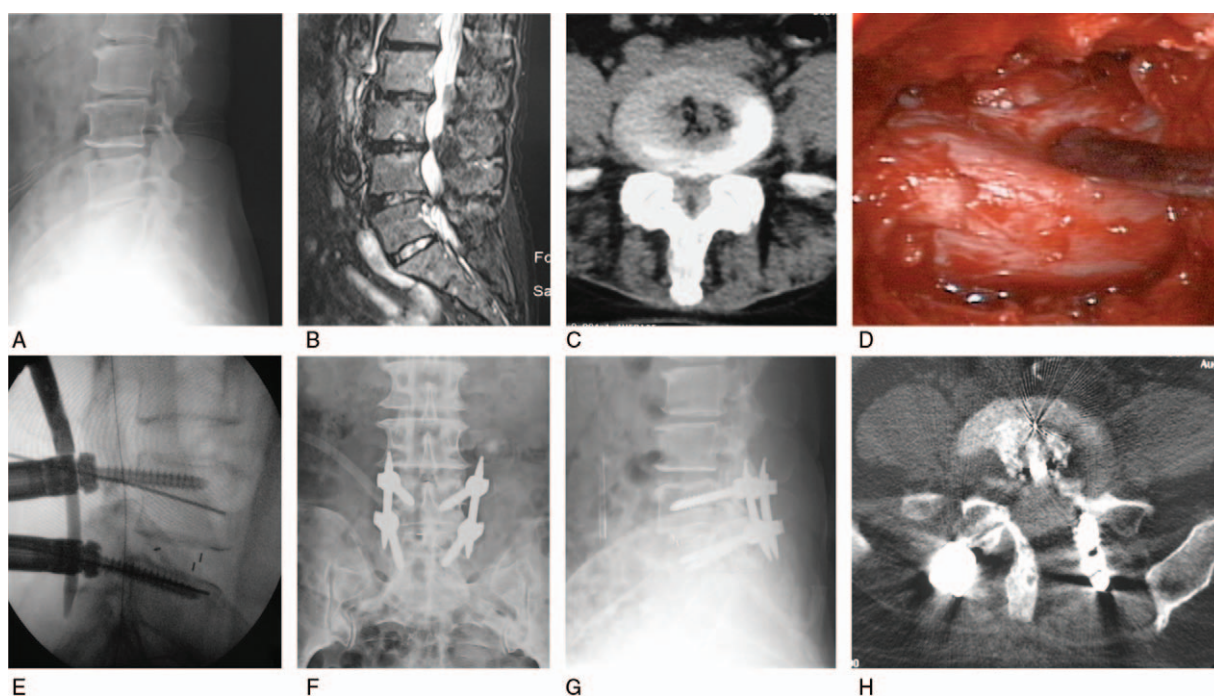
A 60-year-old woman with L4,5 spinal stenosis and retrospondylolisthesis had claudication for 8 years, she was treated with bilateral decompression via left fenestration and intervertebral fusion using the MMED technique. The symptoms resolved after operation with Macnab excellent results. (A) Preoperative x-ray showing L4/5 retrospondylolisthesis. (B) Preoperative MRI showing L4,5 disc protrusion and canal stenosis. (C) Preoperative CT scans showing L4,5 bilateral spinal stenosis. (D) Intraoperative endoscopic vision showing bilateral sufficient decompression. (E) Intraoperative fluoroscopy showing that spondylolisthesis was reduced by cage and percutaneous pedicle screw system. (F and G) Postoperative anteroposterior and lateral x-ray showing good positioning of cage and implants. (H) CT scans showing bone graft around cage and bilateral decompression with nearly intact contralateral lamina. CT = computed tomography, MMED = mobile microendoscopic discectomy, MRI = magnetic resonance imaging.
